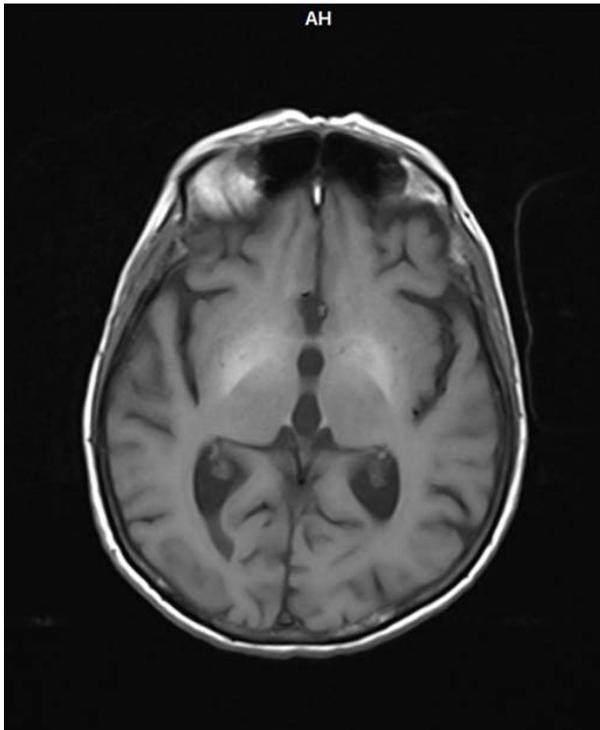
Axial MRI T1-weighted image shows typical symmetrical hyperintense signal changes in bilateral globus pallidi.
